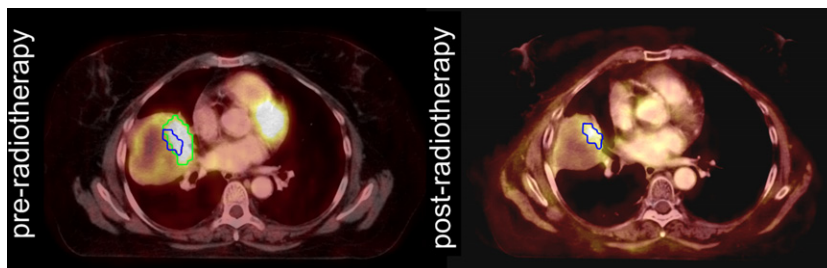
FDG-PET-CT scans before and 3 months after radiotherapy of a single patient. The green contour is the 50% SUV_{max} contour and the blue contour represents the location of the residual metabolic active areas after radiotherapy. The overlap of the contours was on average 70% for 22 patients [15]. Parts of this figure have been published previously in reference [15]. See power point version of the figure in the Supplementary data.
